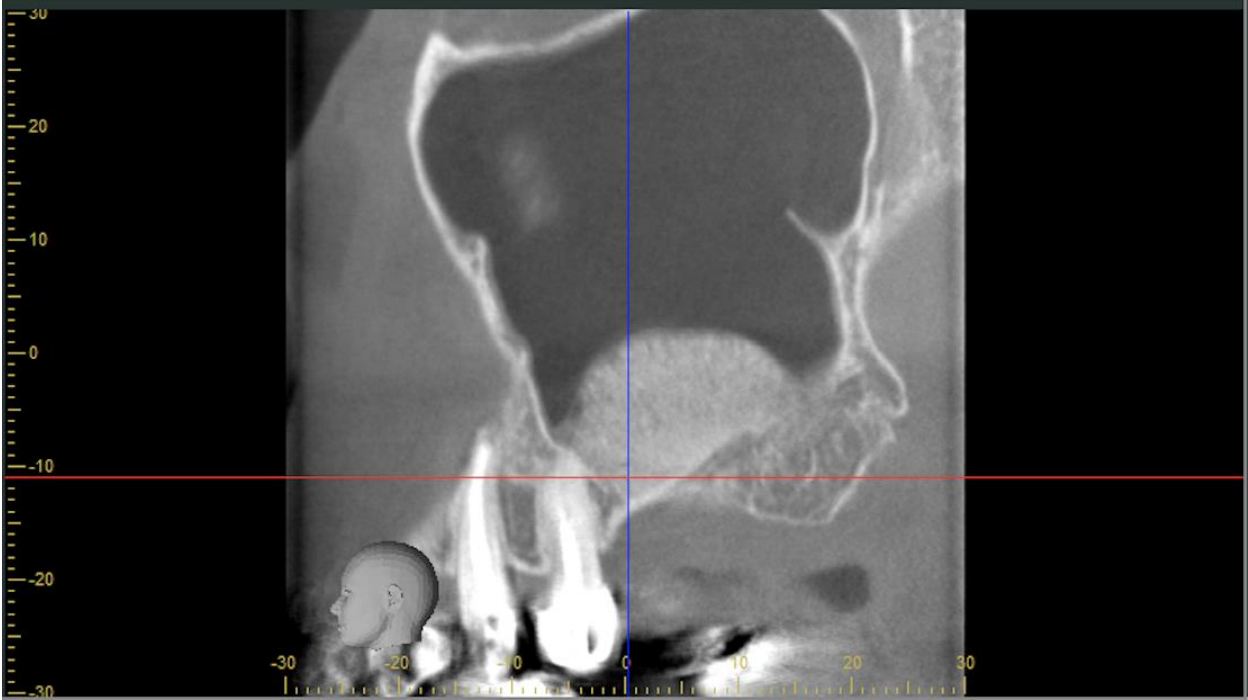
Post-operative cone beam computed tomography (CBCT) images
